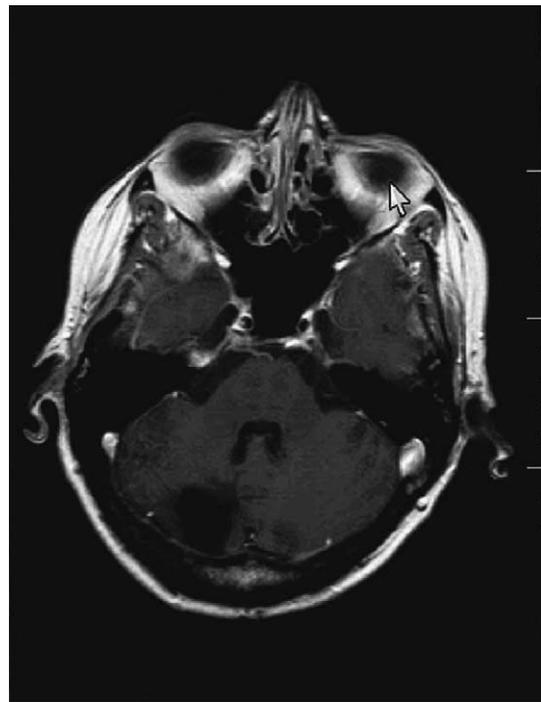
MRI axial T1-weighted (TR = 627, TE = 17), post-gadolinium contrast exam through the posterior fossa demonstrating a 3-cm-diameter nonenhancing defect in the posterior aspect of the right cerebellar hemisphere in the post-surgical bed at the location of the previously demonstrated metastasis.
